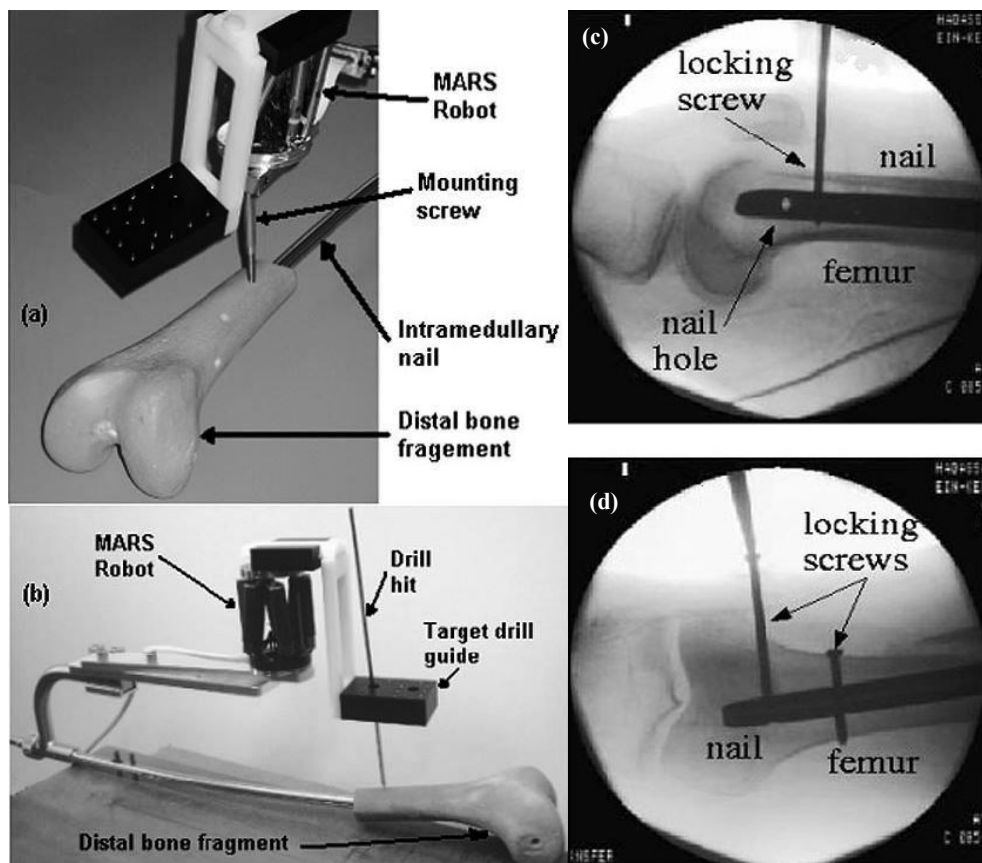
Photograph of the *MARS* robot mounted (a) on the femur (b) on the nail head, and X-ray fluoroscopic images showing (c) the distal part of the femur and the intramedullary nail with two distal locking nail holes, (d) the intramedullary nail with two distal locking screws. (Image source: Shoham et al. (130))
